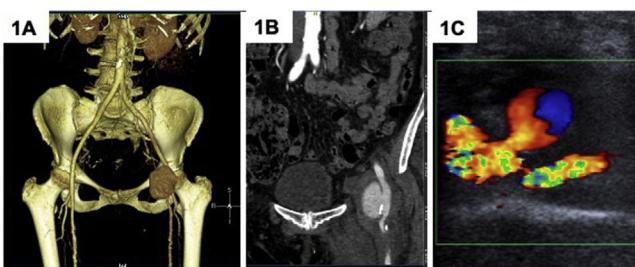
A-B) Caoe 1. CT angiography shows at the level of the left common femoral artery a large FAP of 5.3 cm maximum diameter with communication with the neckless artery. C) Case 2. Arterial Doppler shows a small collection of 1.5 cm in diameter medial to the right distal common femoral artery; it presents filling with back-and-forth arterial flow and has a short neck.
